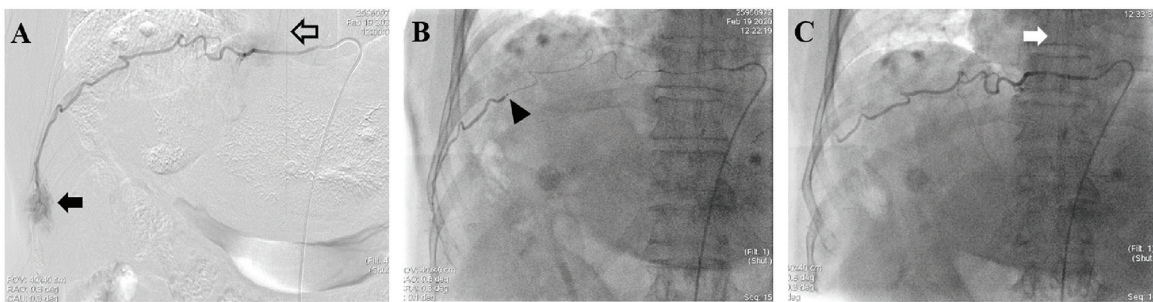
The angiography of the right 9th intercostal artery revealed hypervascular mass at the chest wall (black arrow), corresponding to the mass from CT scan (A). The anterior spinal artery originates from the proximal part of the intercostal artery (open arrow) (A). The tip of the microcatheter was placed at the distal part of the intercostal artery (arrowhead) (B). Post chemo-infusion image showed patent of anterior spinal artery (white arrow) (C).
